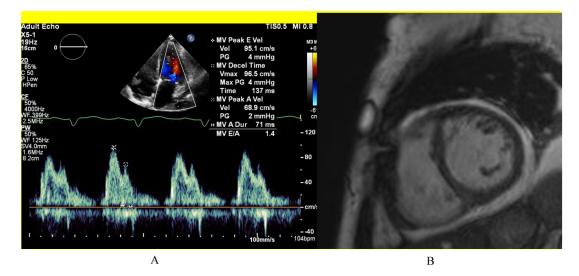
(A) Cardiac Echocardiogram mitral inflow and (B) Cardiac MRI
